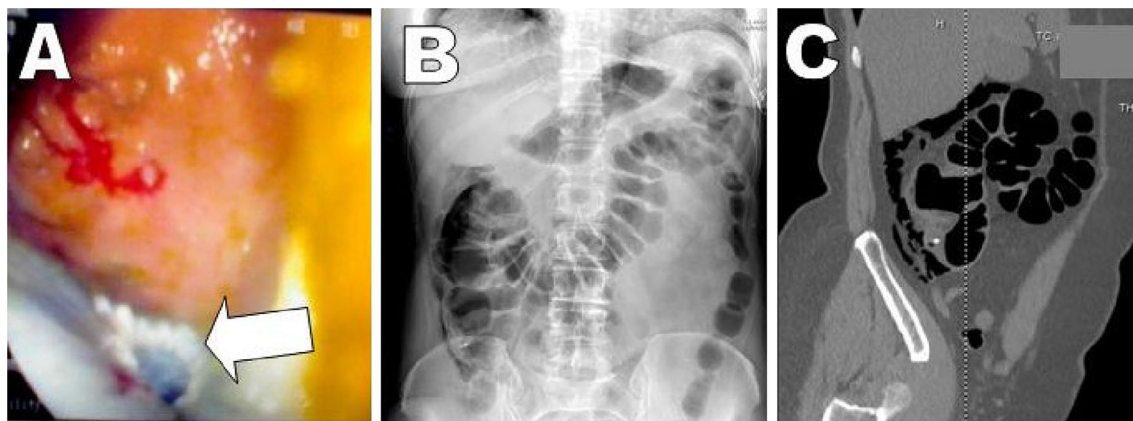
Postendoscopic mucosal resection (EMR) perforation (*white arrow*) (a) with free air in the abdomen on X-ray (b) and computed tomography scan (c)
